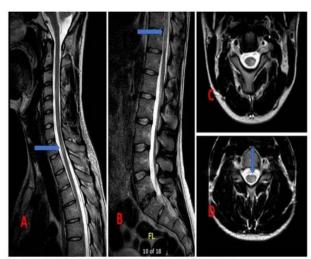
Sagittal T2 MRI spine shows Multiple short segmental patchy focal areas of T2 hyperintensities are seen in the cervical and dorsal spinal cord as well as the conus medullaris (horizontal blue arrows in Images 1A and 1B). On Axial T2 imaging (Figs 1C and 1D) I these lesions involves central cord and also of the peripheral sub pial location on left side of the spinal cord indicated by vertical blue arrow.
